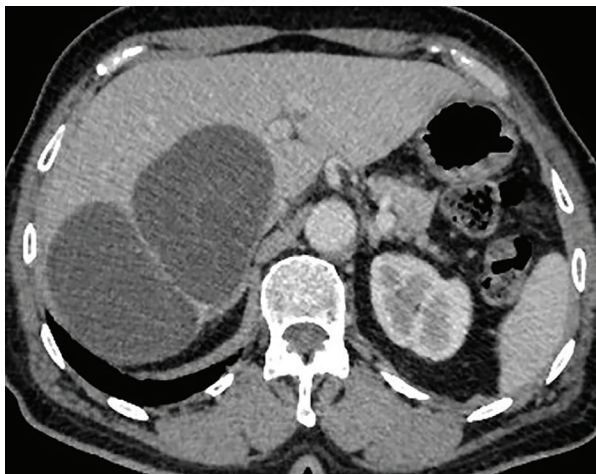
A 38-year-old foreign man was diagnosed with a hydatid cyst in the posterior superior segment of the right hepatic lobe based on computed tomography imaging and laboratory confirmation.
